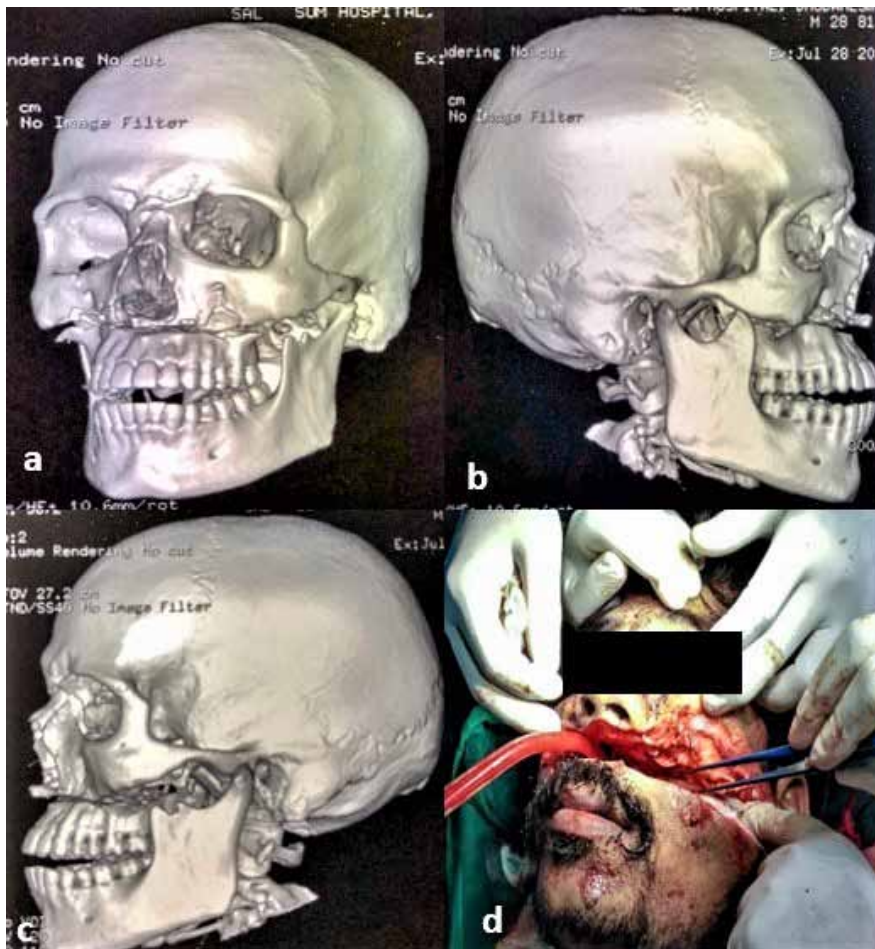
a, b,c : PRE-operative CT showing frontal, right and left view. d: PRE OP pic of patient
